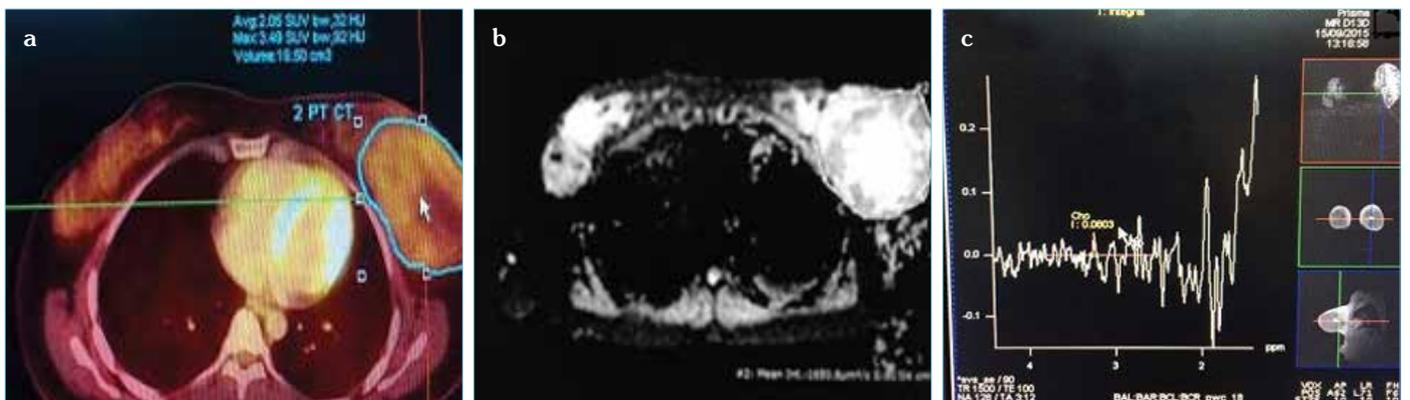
a-c. (a) Circular region of interest (diameter, 1.5 cm) was placed over the tumour in the slice with the maximum SUV :3.49 $\mu\text{g}/\text{dL}$. (b) Circular region was drawn at the breast lesion with b value of 50 showed non-restricted with ADC value of 1.65 mm^2/s which were benign. (c) Peak of tCho with 1.41ppm and integral at 0.08 in benign tumour
